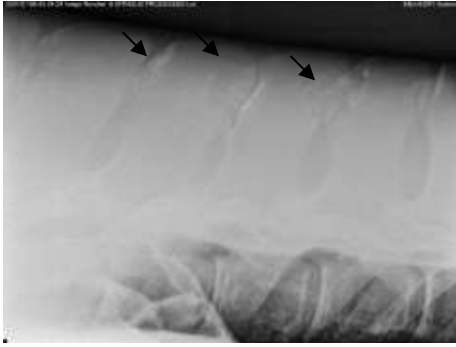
Left lateral digital radiograph showing impingement of numerous mid-caudal thoracic dorsal spinous processes of the back. Significant sclerosis and osteolysis is evident at the affected spinous process summits (black arrows).
